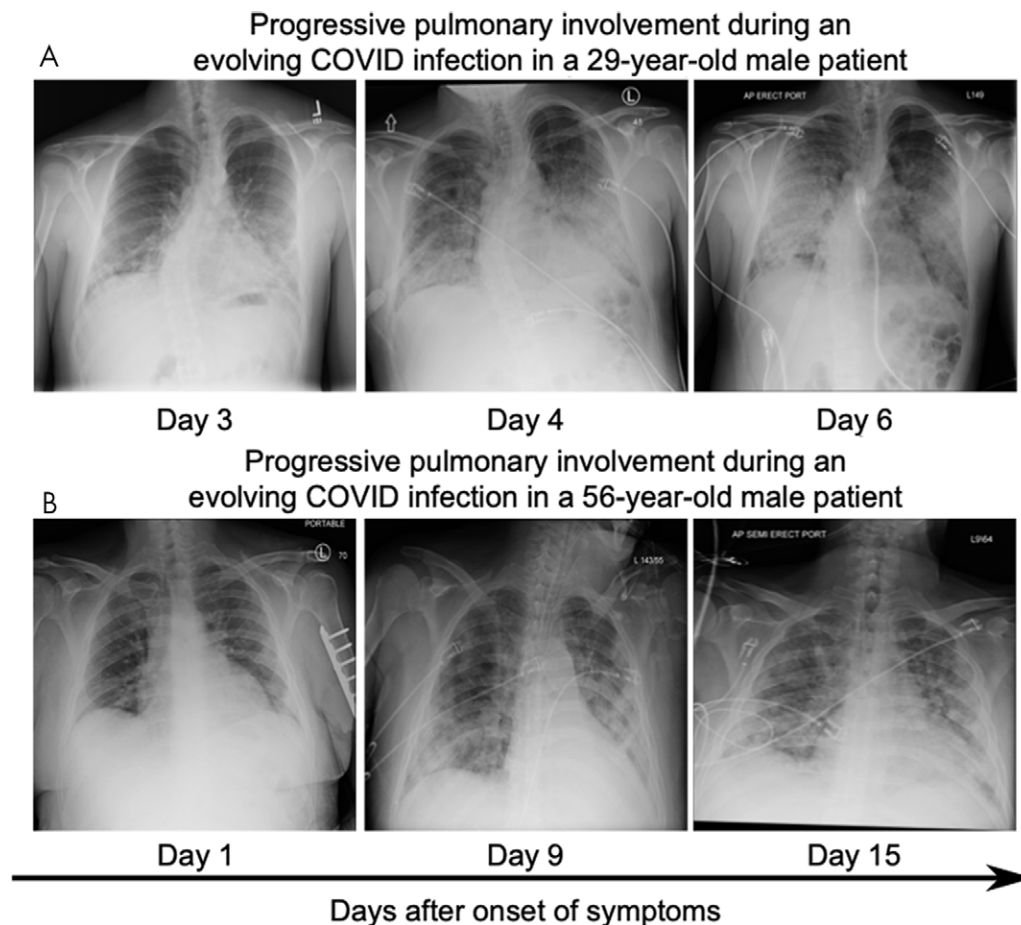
Representative serial chest radiography of patients with COVID-19 infection. A, Images in a 29-year-old man with rapid respiratory deterioration after symptom onset shows progression from lower lung-predominant interstitial and airspace opacities on day 3 to diffuse involvement with extensive airspace disease on days 4 and 6. B, Images in a 56-year-old-man with COVID-19, presenting initially with a normal chest radiograph, which then progressed to lower lung-predominant interstitial and airspace opacities at day 9, which mildly worsened by day 15.
